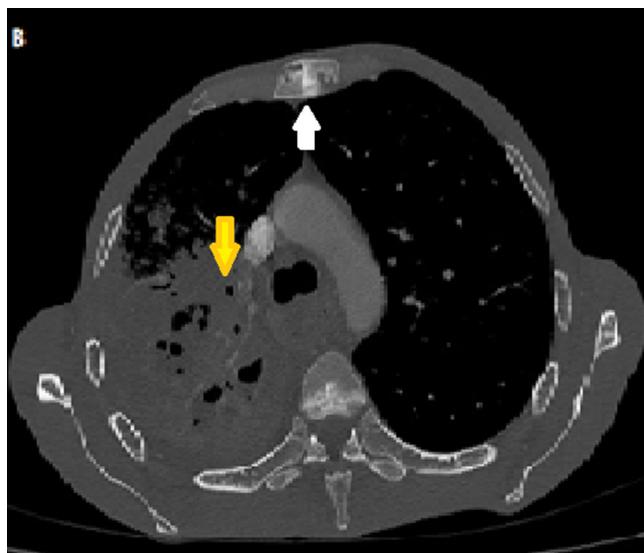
An axial chest CT eight years later, showing the moth-eaten manubrium (white arrow) and signs of an oesophageal bronchial fistula (yellow arrow)
